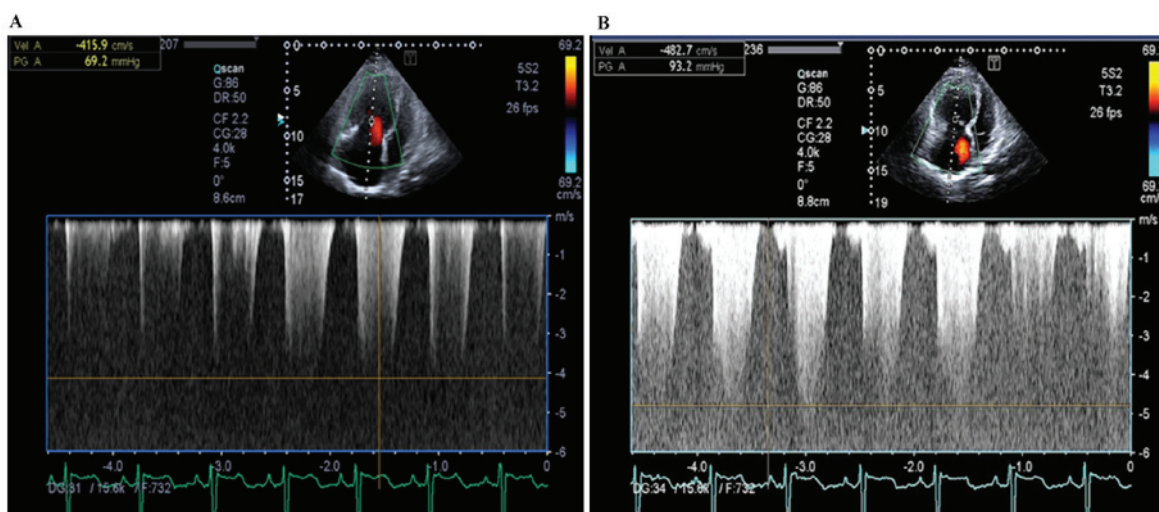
Echocardiography performed on a 36-year-old female with pulmonary hypertension. (A) Tricuspid regurgitation Vel was 415.9 cm/sec and the PG was 69.2 mmHg. (B) Contrasted echocardiography of the right side of the heart revealed a tricuspid regurgitation Vel of 482.7 cm/sec with a PG of 93.2 mmHg. Vel, velocity; PG, pressure gradient.
